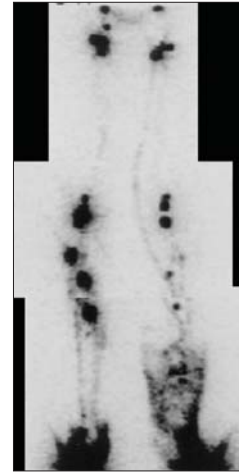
Lymphoscintigram of lower limbs months after mosquito bites. Swollen left leg with spread of isotope in the skin and subcutaneous tissue. Visualized popliteal lymph nodes. In the right limb, enlarged popliteal and inguinal nodes
